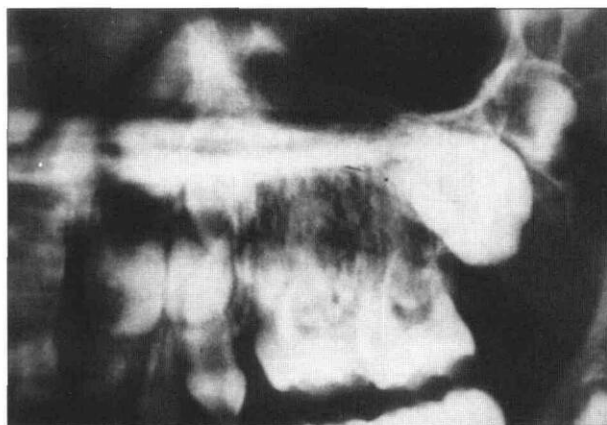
Periapical radiograph of the left maxillary molar region. A coarse, irregular bone pattern is seen. Premolars are absent or extremely hypoplastic.
